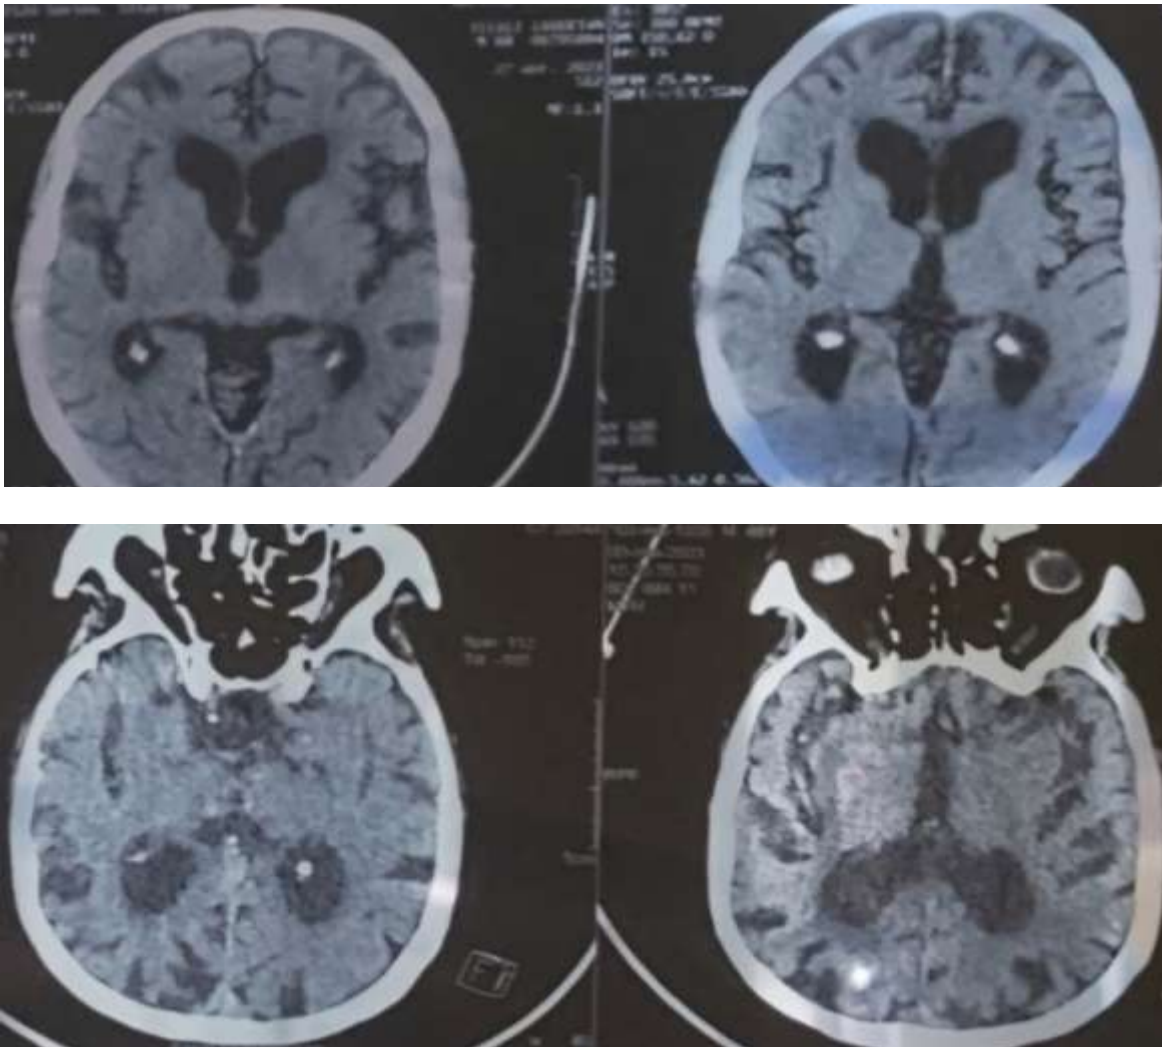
Brain scan CT demonstrating bilateral symmetric calcifications of the choroid plexus and of the brain scythe in a patient with Fahr's syndrome and cardiac conduction anomalies.
